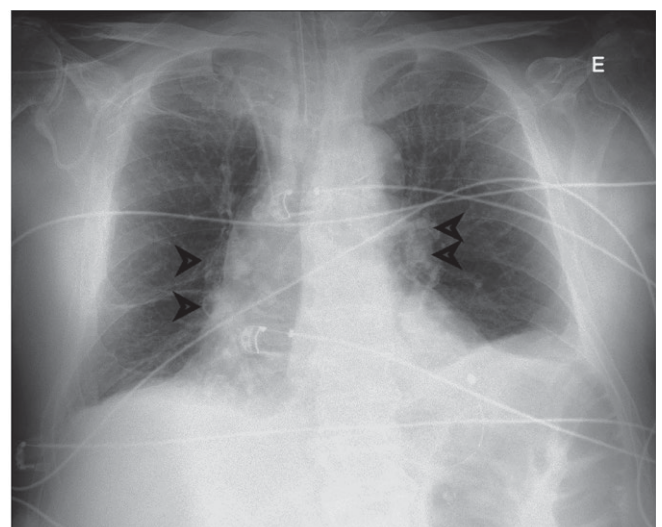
Plain X-ray posteroanterior view showing bilateral hilar adenopathy with eggshell calcification (black arrows).
